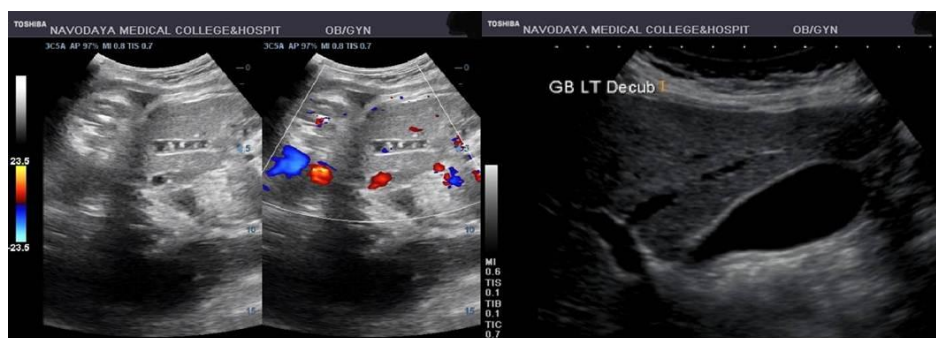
A 30 weeks fetus showing presence of echogenic solid debris within the gall-bladder. A follow-up sonography at 6 months of birth showing complete resolution.
